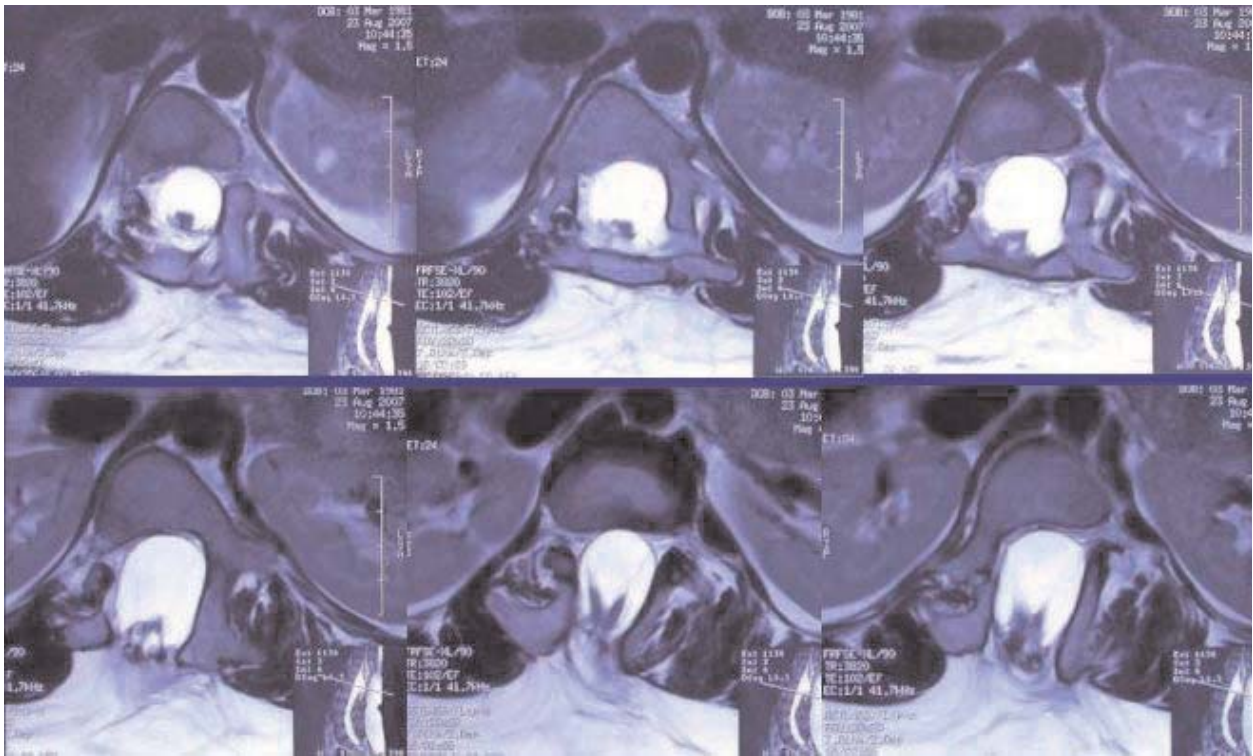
T2- weighted aksiyal lomber MRI showing posterior fusion defect at the level of L1 vertebrae, enlargement of postero-anterior diameter of spinal canal, posterior displacement of spinal cord and attachment to the subcutaneous tissue (tethering). Diplomyelic appearance between T11 and L2 level and intradural lipom on the posterior of the cord at the T11 and T12 level.
